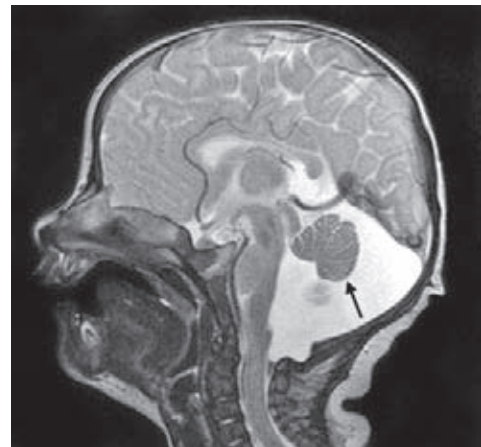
Dandy-Walker malformation. Sagittal T2 MR image shows enlarged posterior cranial fossa with mild hypoplasia of the cerebellar vermis (arrow)
